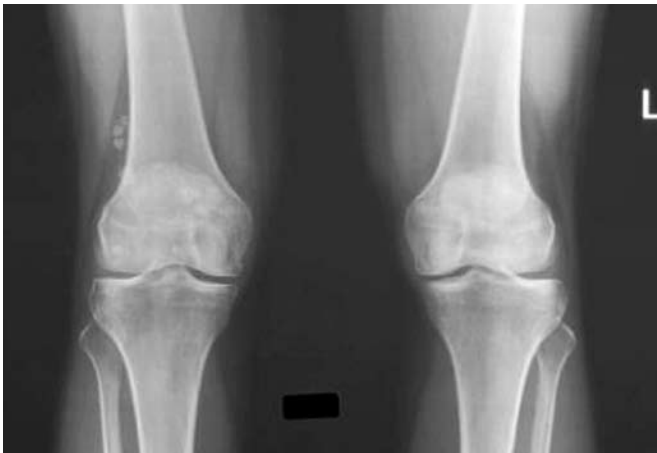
Anteroposterior knee radiograph of a 43-year-old woman with synovial osteochondromatosis shows multiple dense rounded loose bodies in and around the right knee, conforming to the capsular margins of the knee joint.
